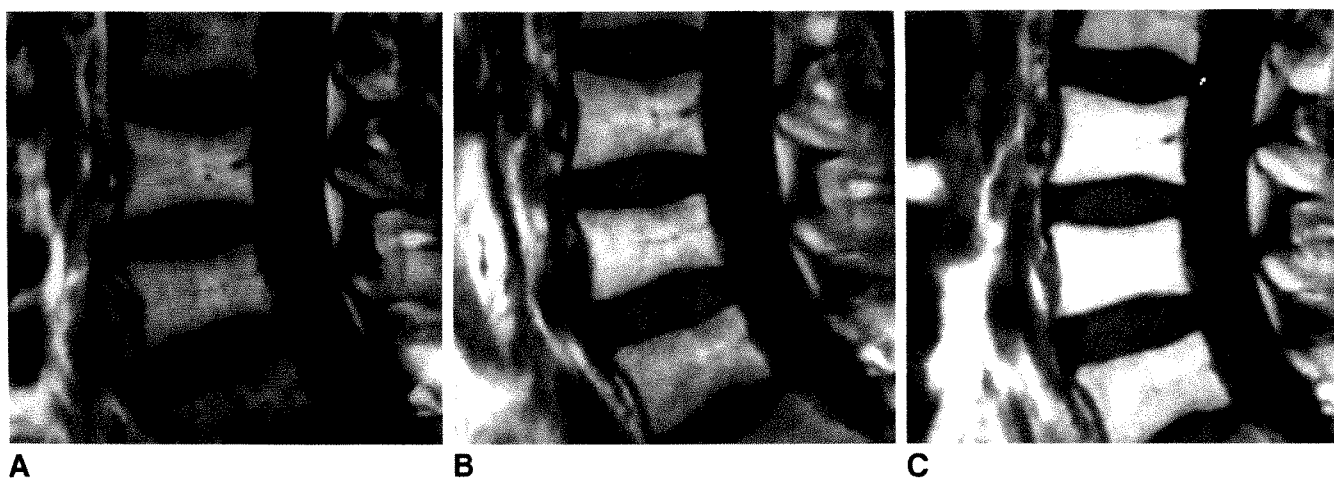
Sagittal T1-weighted spin-echo images (300/30) of lumbar spine in 34-year-old patient with seminoma.
